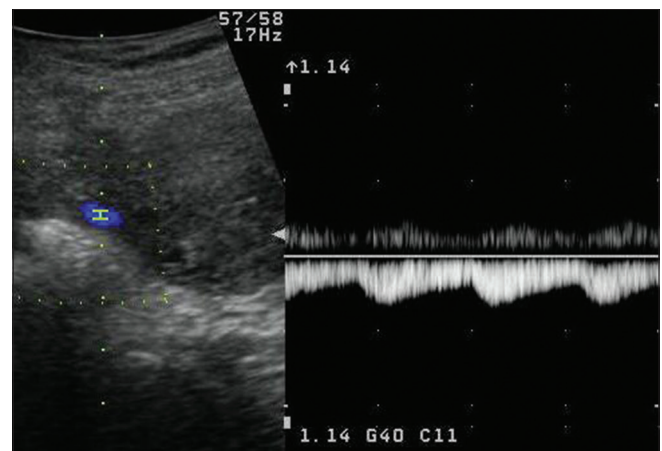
Spectral Doppler image in another patient showing characteristic to-and-fro flow waveform in right uterine artery pseudoaneurysm
